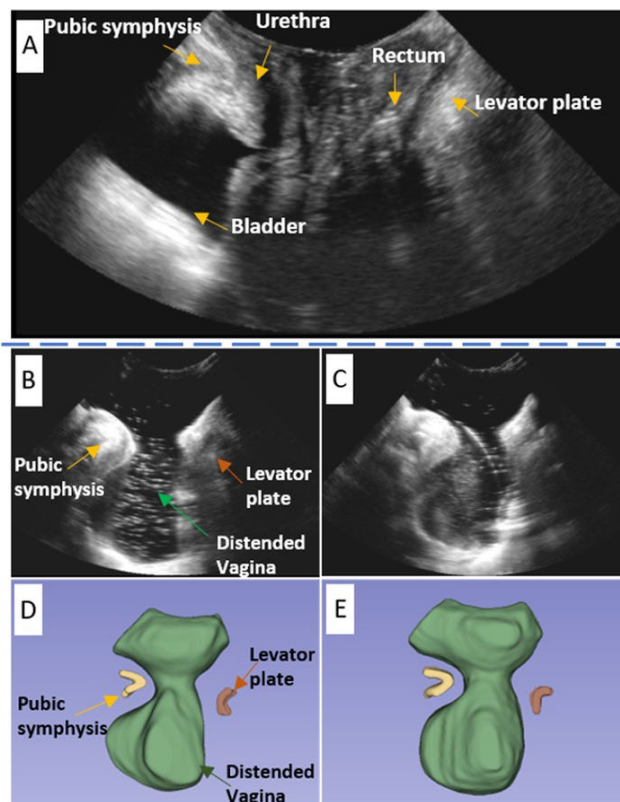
(A) Midsagittal view of a 3D transperineal ultrasound image without vaginal distension (i.e., baseline ultrasound). (B) and (C) the midsagittal CDI images of the distended vagina in Round A and Round B, respectively. The images were captured two hours apart in the same patient. (D) and (E) 3D surface model segmentation of the distended vagina (in green) relative to the pubic symphysis (in yellow) and levator plate (in brown) in Round A and Round B, respectively.
